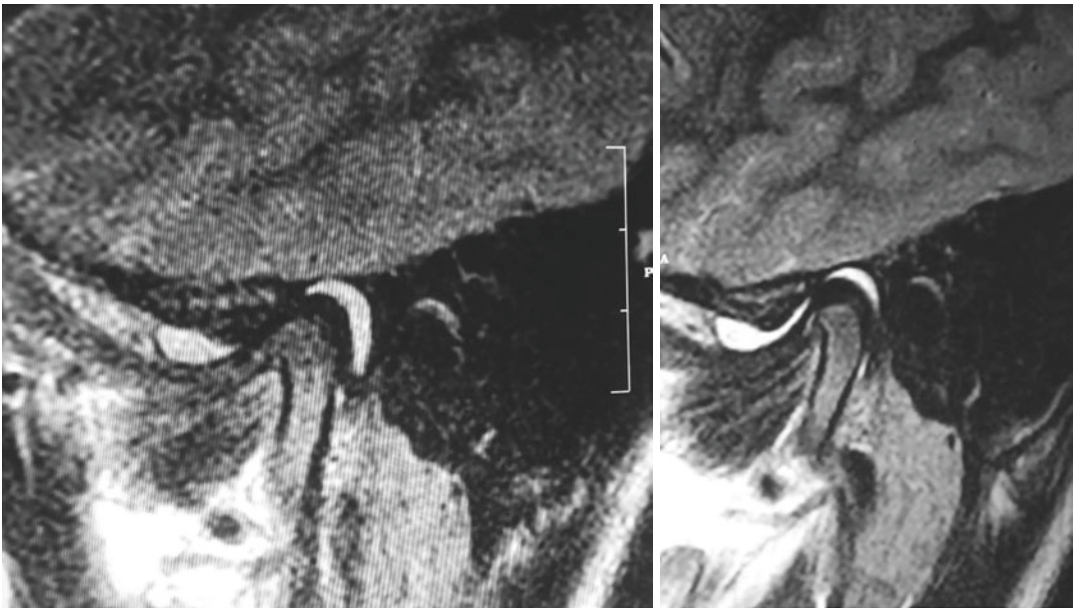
MRI showing effusion in the joint space in a T2 weighted MRI in open and closed mouth position (Image courtesy: Dr. Darpan Bhargava, Private case, Oral and Maxillofacial Surgery, TMJ Consultancy, Bhopal, India)
